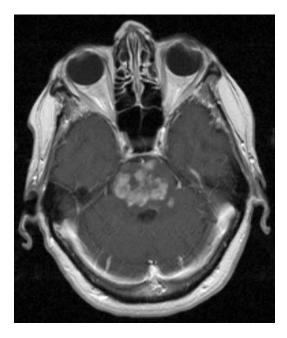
Magnetic resonance imaging of a 70-year-old woman with progressive brain stem symptoms. Biopsy showed Erdheim-Chester disease with a *BRAF V600E* mutation
